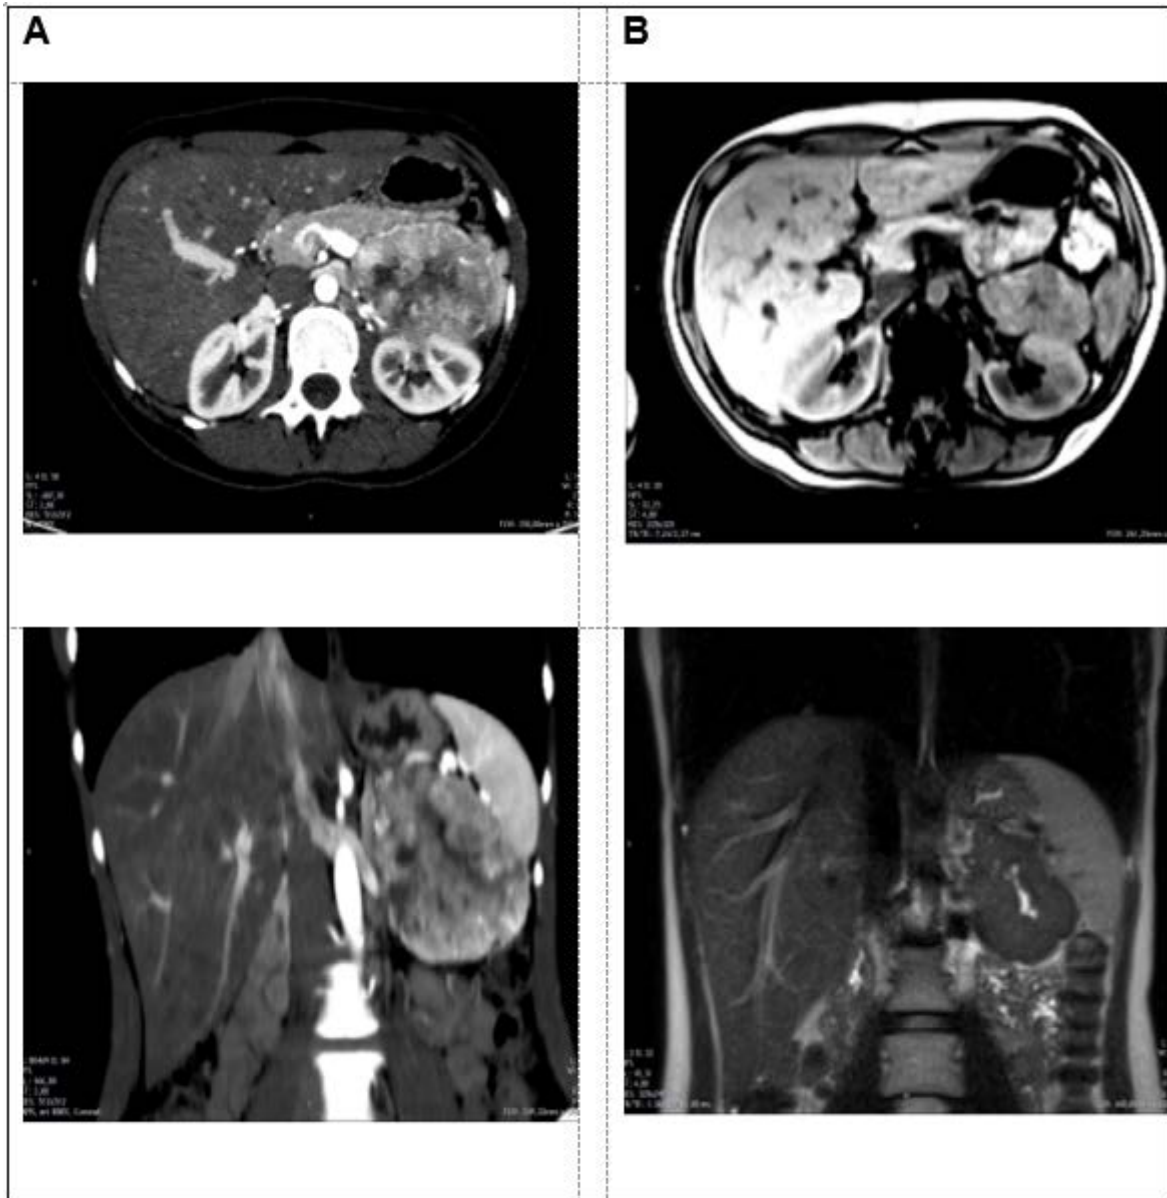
Contrast-enhanced abdominal CT and MRI images of the patient before (A) and after (B) 3 months of everolimus 2.5 mg/day treatment.
